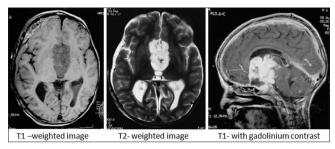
Magnetic resonance image of brain showing a sellar and suprasellar mass lesion, which was hypointense on T1-weighted image, hyperintense on T2-weighted image and intensely enhancing with gadolinium contrast
